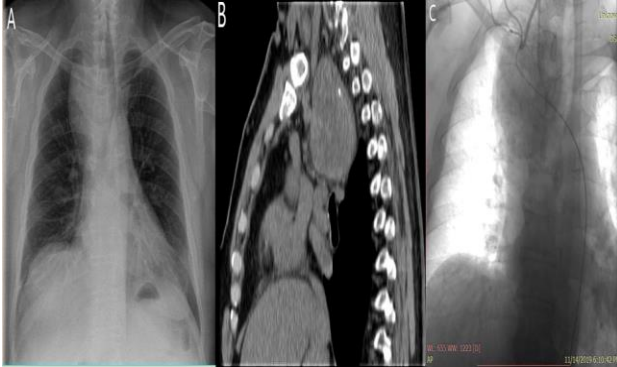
(A) C X-ray showing the right posterior mediastinal mass causing tracheal displacement, (B) CT scan confirming the extend and location of the mass and (C) selective catheterization of the brachiocephalic artery, showing aberrant artery arising from the thyrocervical trunk at the level of RIMA close to the origin of the vertebral artery.
